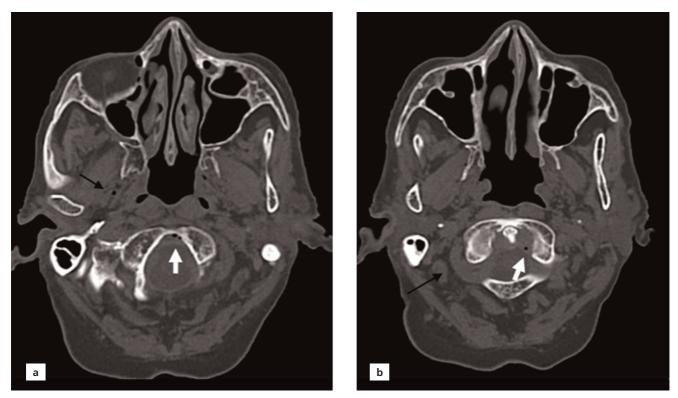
Bone window images of nonenhanced cranial CT. (a) Air bubbles in cervical epidural venous plexus at the level of foramen magnum (white arrow) and in the right pterygoid venous plexus (black arrow); (b) air bubbles in cervical epidural venous plexus at the level of cervical spine (white arrow) and in the right vertebral artery venous plexus (black arrow).
